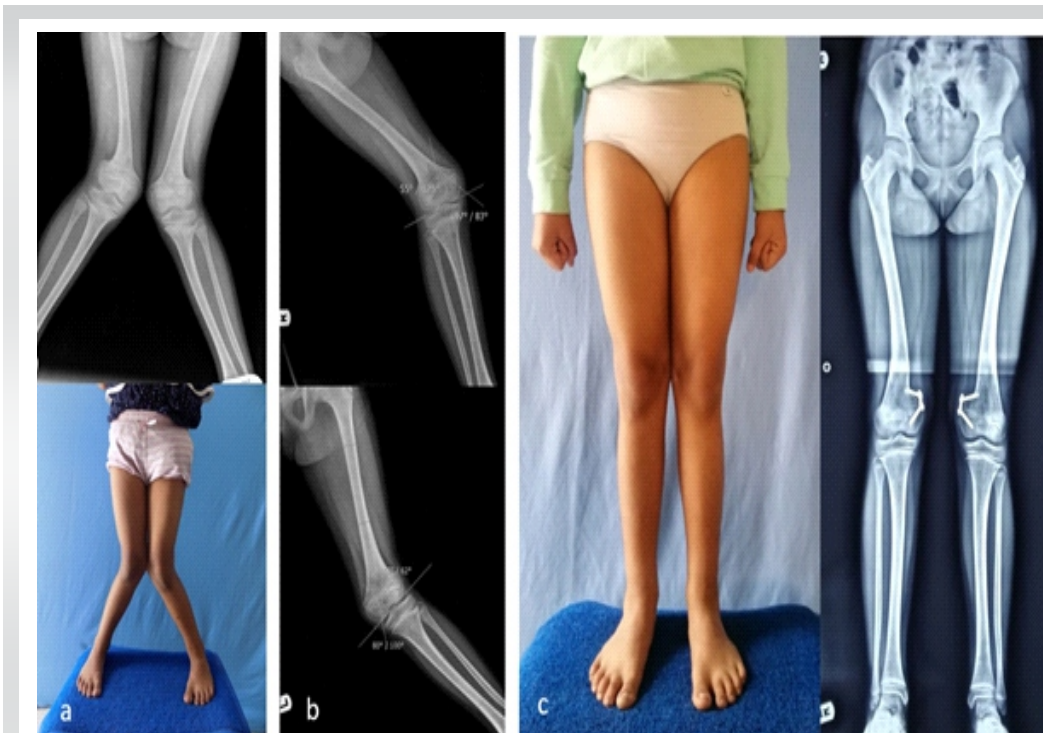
a. F/9 years (Patient no 12) with bilateral genu valgum with signs of active rickets, b. X-ray before surgery after six weeks of medical treatment showing healed rickets and distal femoral valgus, c. Excellent deformity correction 18 months after bilateral distal femoral 8 plate application
